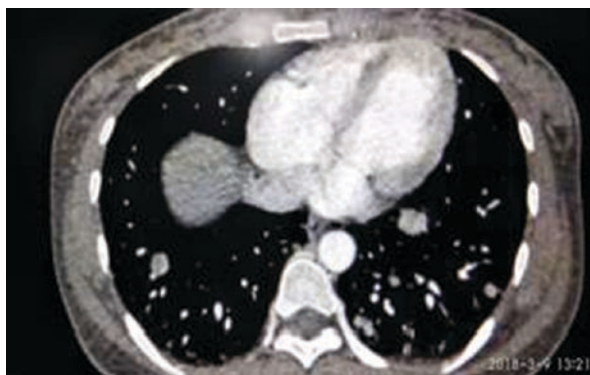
CECT thorax showing multiple lung metastases in a patient of GTN presenting with haemoptysis where chest X-ray was inconclusive
